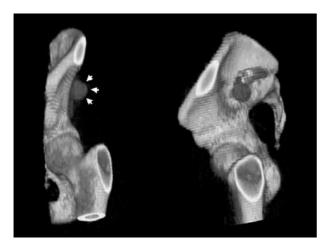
CT scan 3-D reconstruction
